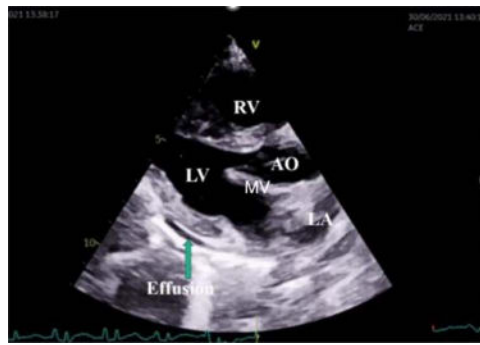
Parasternal long-axis (PLAX) ultrasound view. Note the effusion seen as the anechoic fluid accumulation in the pericardium. LV, left ventricle; RV, right ventricle; LA, left atrium; AO, aorta; MV, mitral valve (figure courtesy of Vrushali Ponde).
